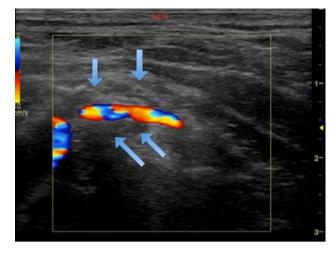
Ultrasound image of right supraclavicular region with color Doppler. *Arrows* indicate brachial plexus
